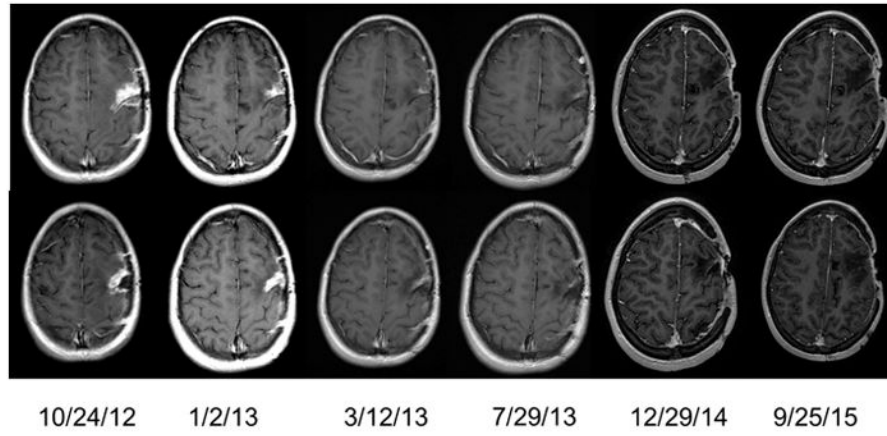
MRI results (T1-weighted gadolinium enhanced images) over the course of time in patient 6.
